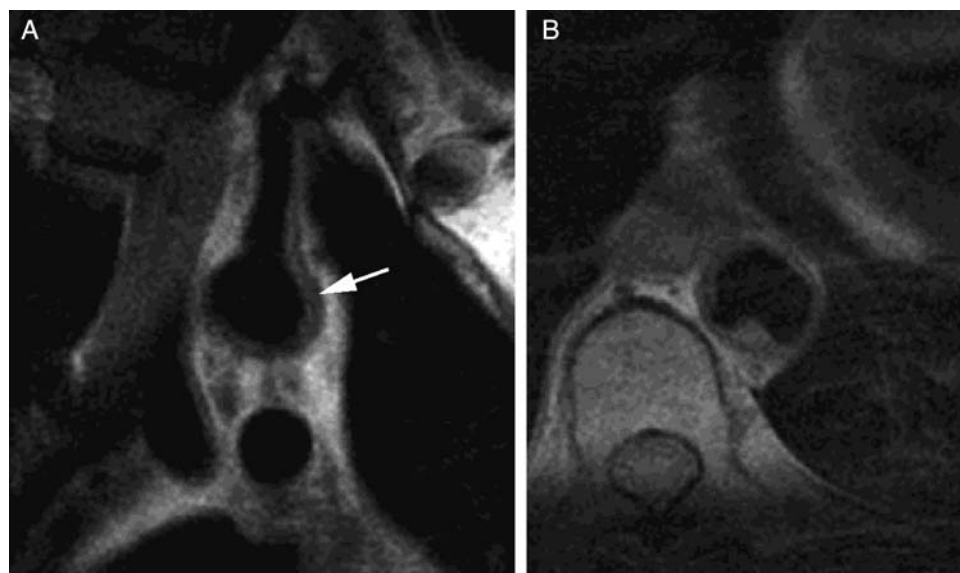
Magnetic resonance imaging high-resolution T2W oblique imaging of the aortic arch demonstrating an atherosclerotic plaque particularly evident in the posterior wall (arrow) extending in the left subclavian artery (A). (B) A protruding 4 mm thick plaque at the level of the distal thoracic aorta.
